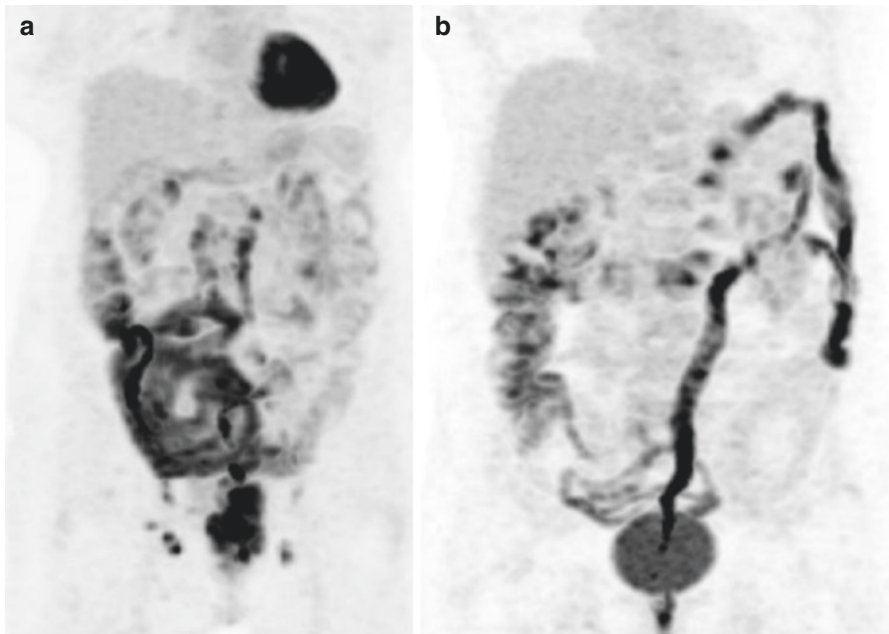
High FDG uptake in bowel in patients on metformin
